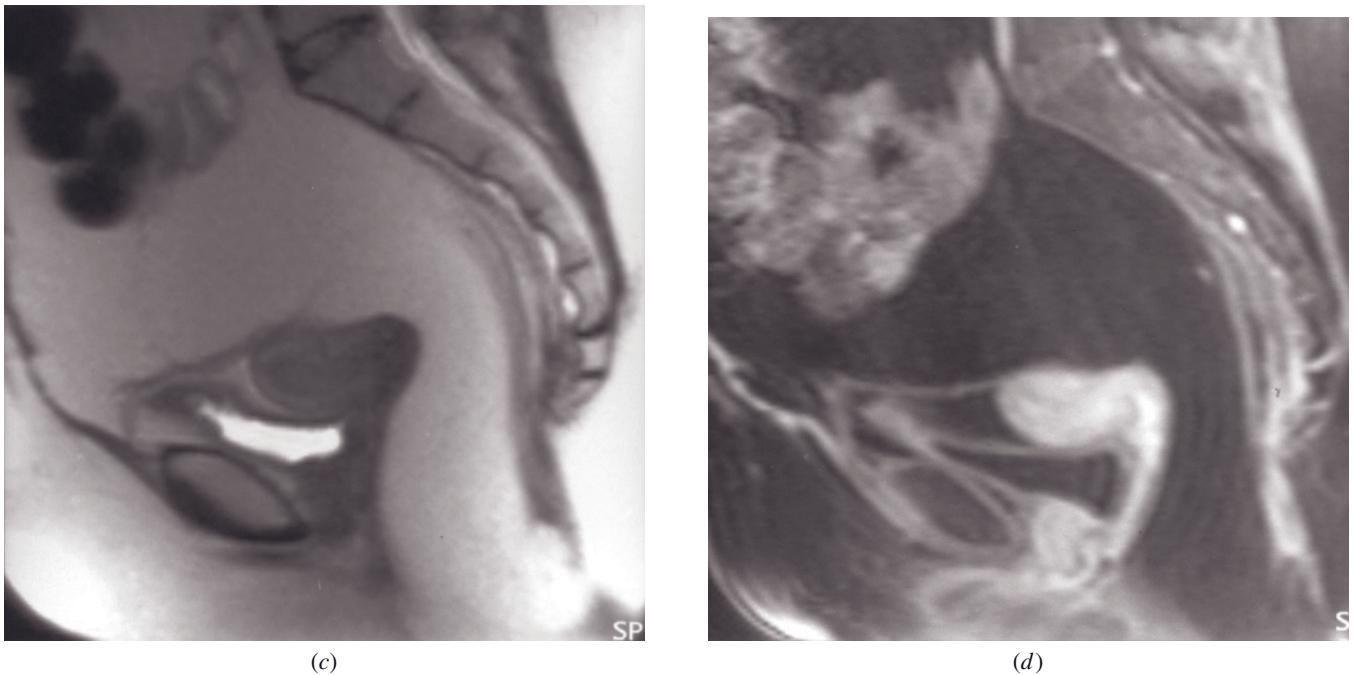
(Continued) Sagittal T2-weighted SS-ETSE (c) and sagittal interstitial-phase gadolinium-enhanced fat-suppressed SGE (d) images in a second patient show increase of pelvic fat consistent with omental packing.
